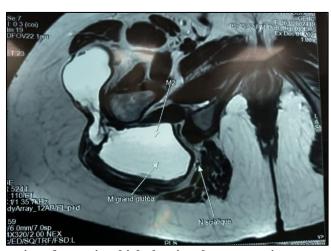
MRI section of posterior thigh showing thwo commnicate cases of cyst hydatic
